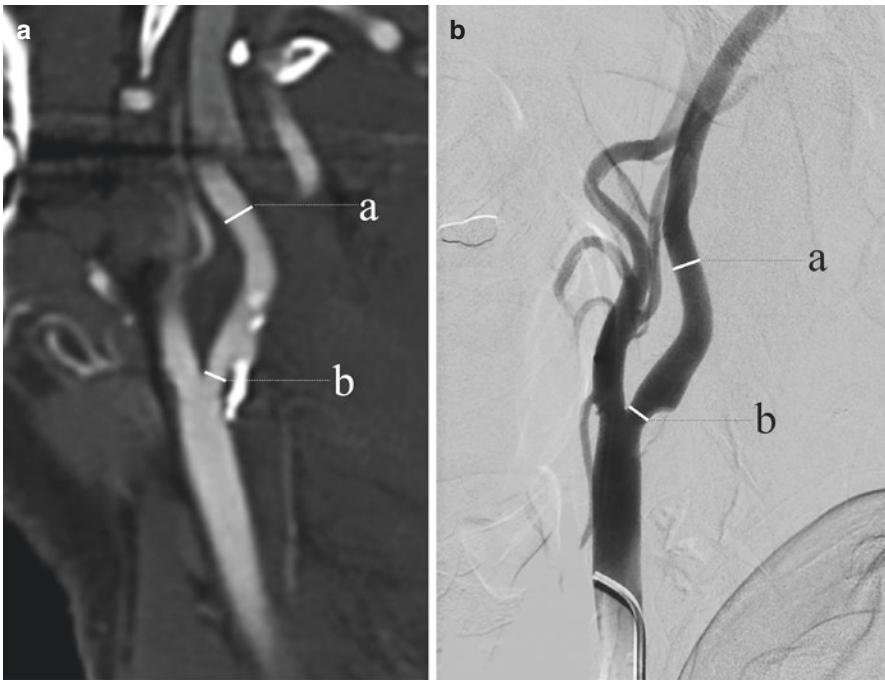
CTA and DSA NASCET criteria for carotid stenosis measurement. Sagittal CTA image through the right carotid bifurcation demonstrates a partially calcified atherosclerotic plaque which results in luminal narrowing of the proximal right internal carotid artery (a). Percent diameter stenosis is calculated using NASCET criteria, where the diameter at the stenosis (b) is compared to a downstream segment of the ICA (above the carotid bulb) without narrowing (a). Stenosis is calculated by the equation $100 * (a - b)/a$. DSA in the same patient demonstrates luminal narrowing with NASCET measurements again shown (b). Note that DSA in this case provides information about the degree of luminal stenosis only, with no information on plaque composition
